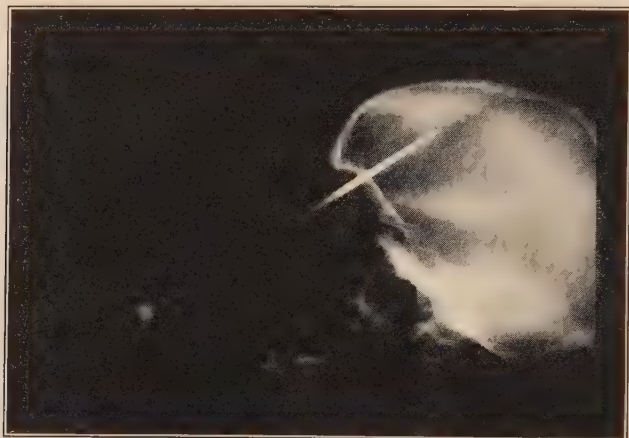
X-ray with leucotome driven in to furthest point.
